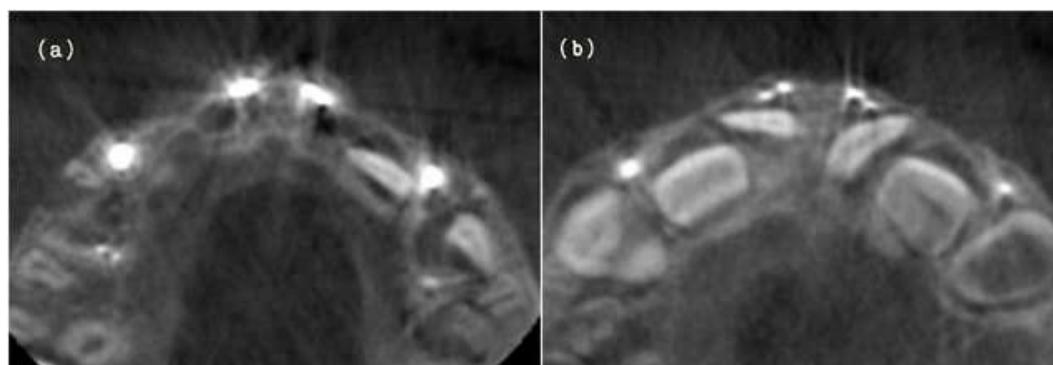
(a) Axial slice of CBCT showing single obturated canal in cervical one third of primary maxillary central incisors.
